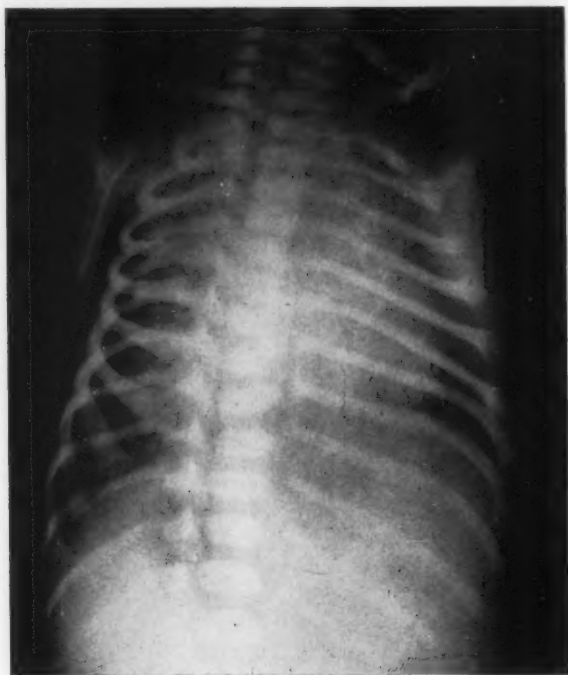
X-rays from Case 3 showing bilateral atelectasis with very little ventilation on either side.
